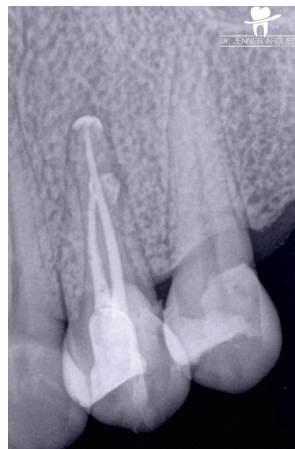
Final mesial x-ray; the separated instrument included in the final obturation can be observed.
